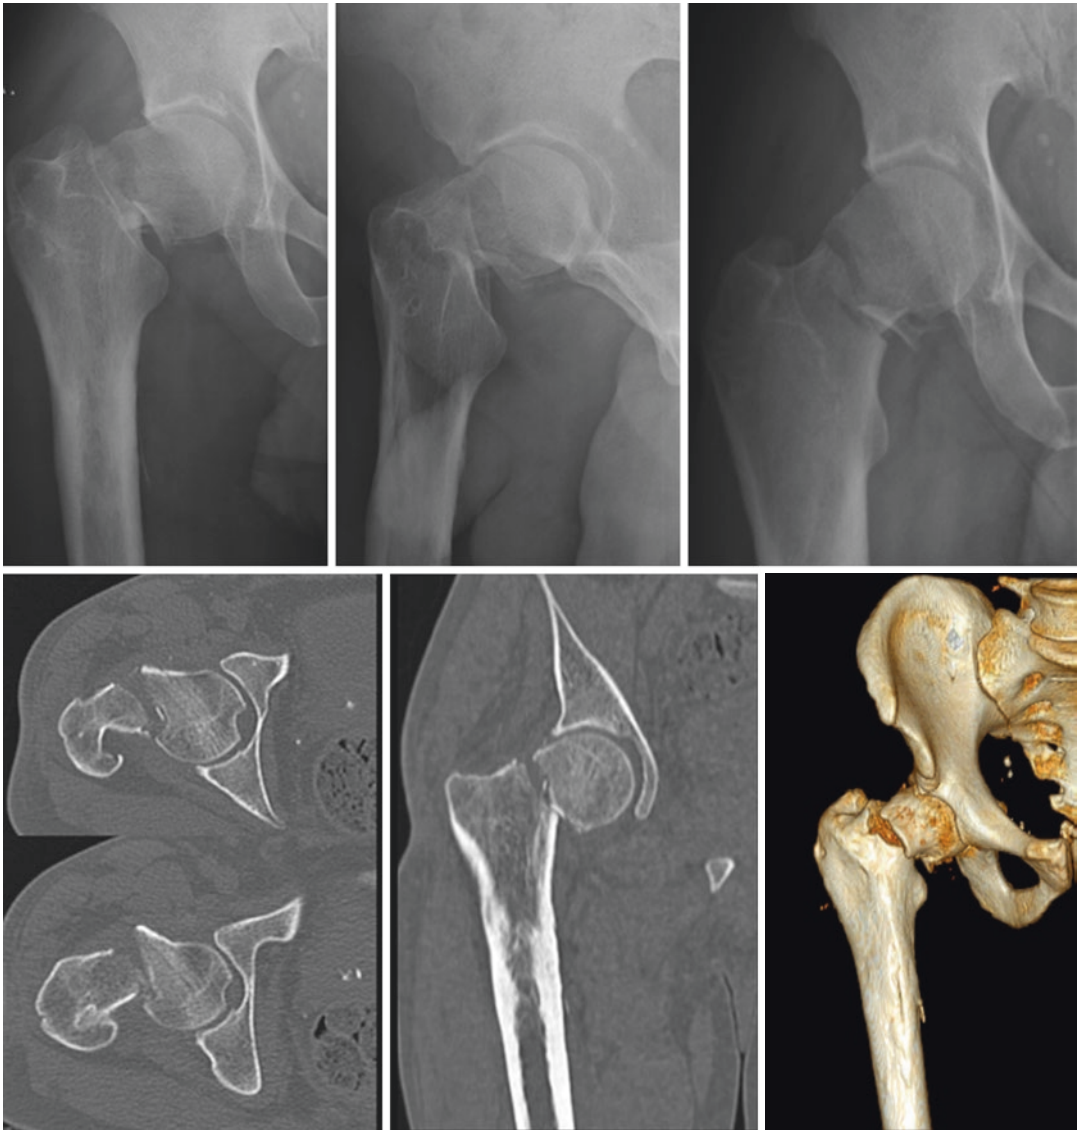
X-ray and CT scan of the intracapsular femoral neck fracture in a 46-year-old male patient after a motorcycle accident
